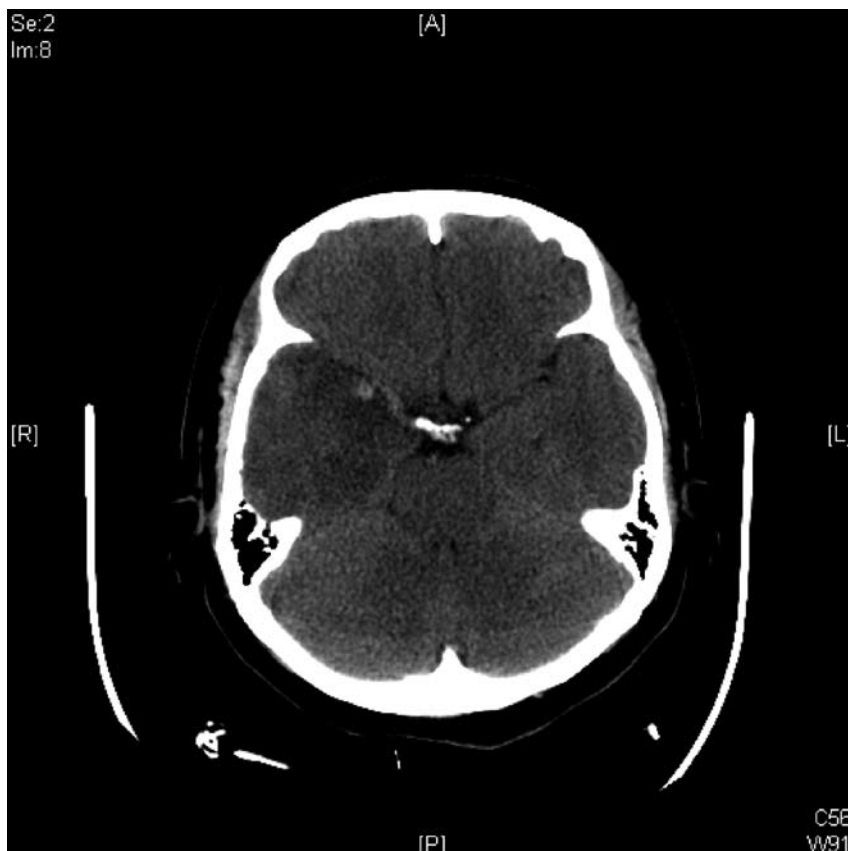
Computed tomograph scan showing hemorrhage in edematous part of brain of patient with herpes simplex virus encephalitis, day 5 of hospitalization.
